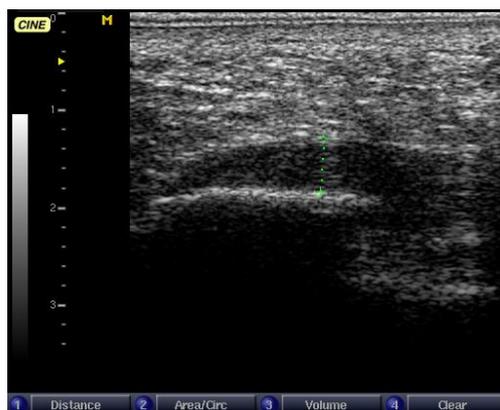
The final thickness of the plantar aponeurosis for one athlete (3 months after the initial ultrasound)
